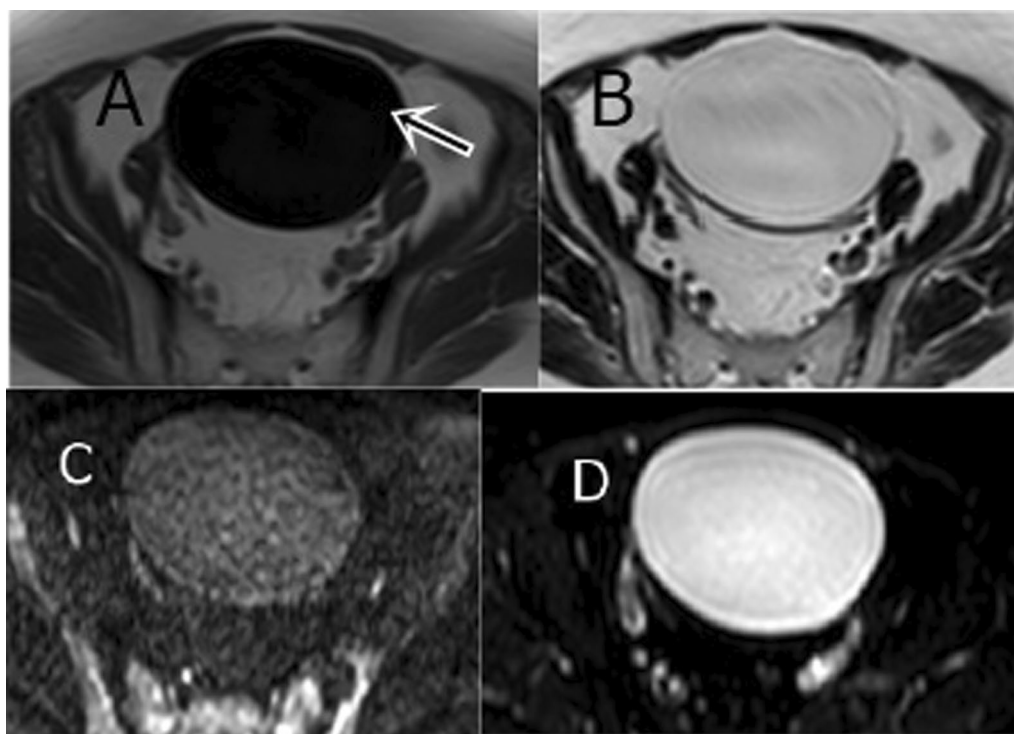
O-RADS MRI score 2 in a 49-year-old female with pelvic pain A Axial T1WI, B axial T2WI, C, D DWI; Right simple ovarian cyst of fluid like SI, no mural nodules, vegetations or soft tissue component
